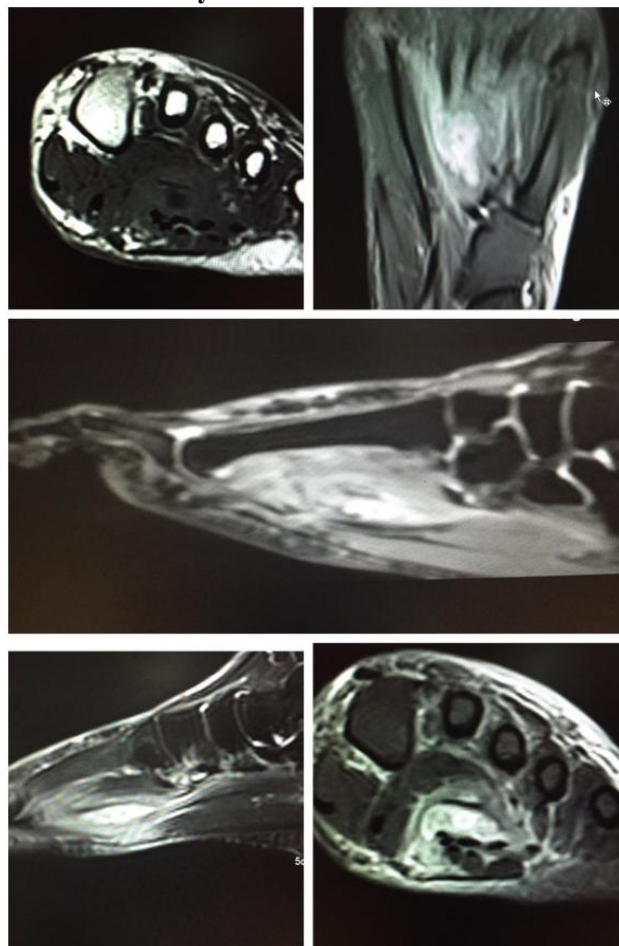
MRI Images both sagittal and coronal sections showing scolex shaped cystic lesions suggestive of soft tissue cystecercosis with associated abscess
